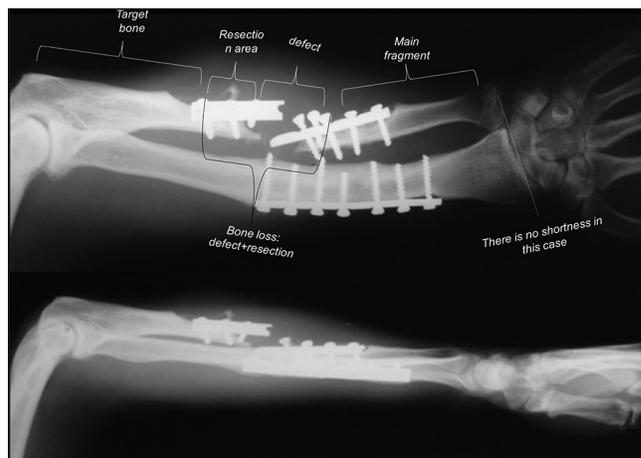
Anteroposterior and lateral radiographs of forearm revealed a large defective ulnar nonunion and a broken plate in a 32-year-old male patient
